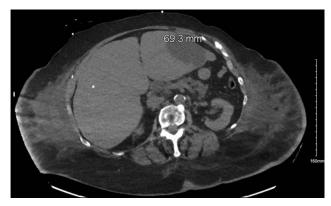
Computed tomography scan demonstrating a large $7.2 \times 5.9 \times 6.9$ cm hypodensity in the patient's liver.
